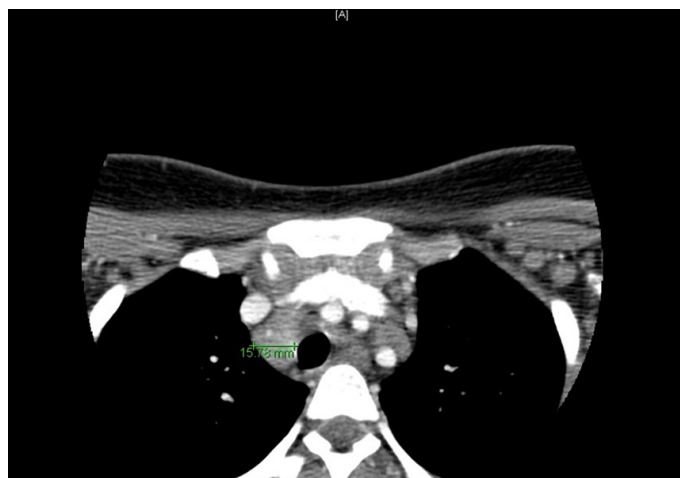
Axial CT scan of the upper mediastinum shows a 15.78 mm lymph node.
